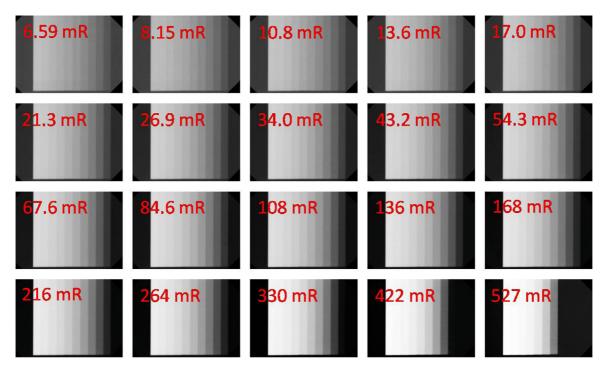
Radiographs of an aluminum step-wedge at incrementally increasing exposures over a range of 20 exposures. *mR*, milli-Roentgens.
